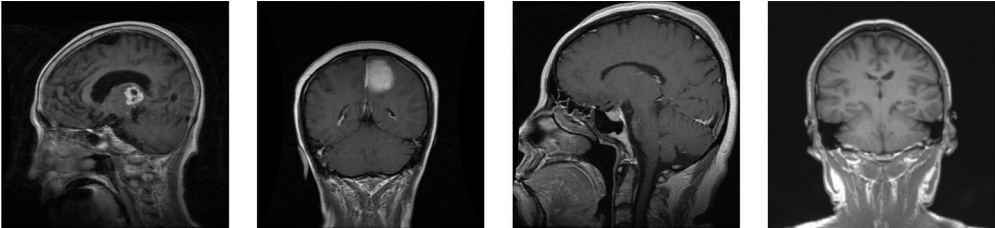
Sample images from brain tumor MRI dataset. From left to right: Glioma, Meningioma, Pituitary, No-tumor.
